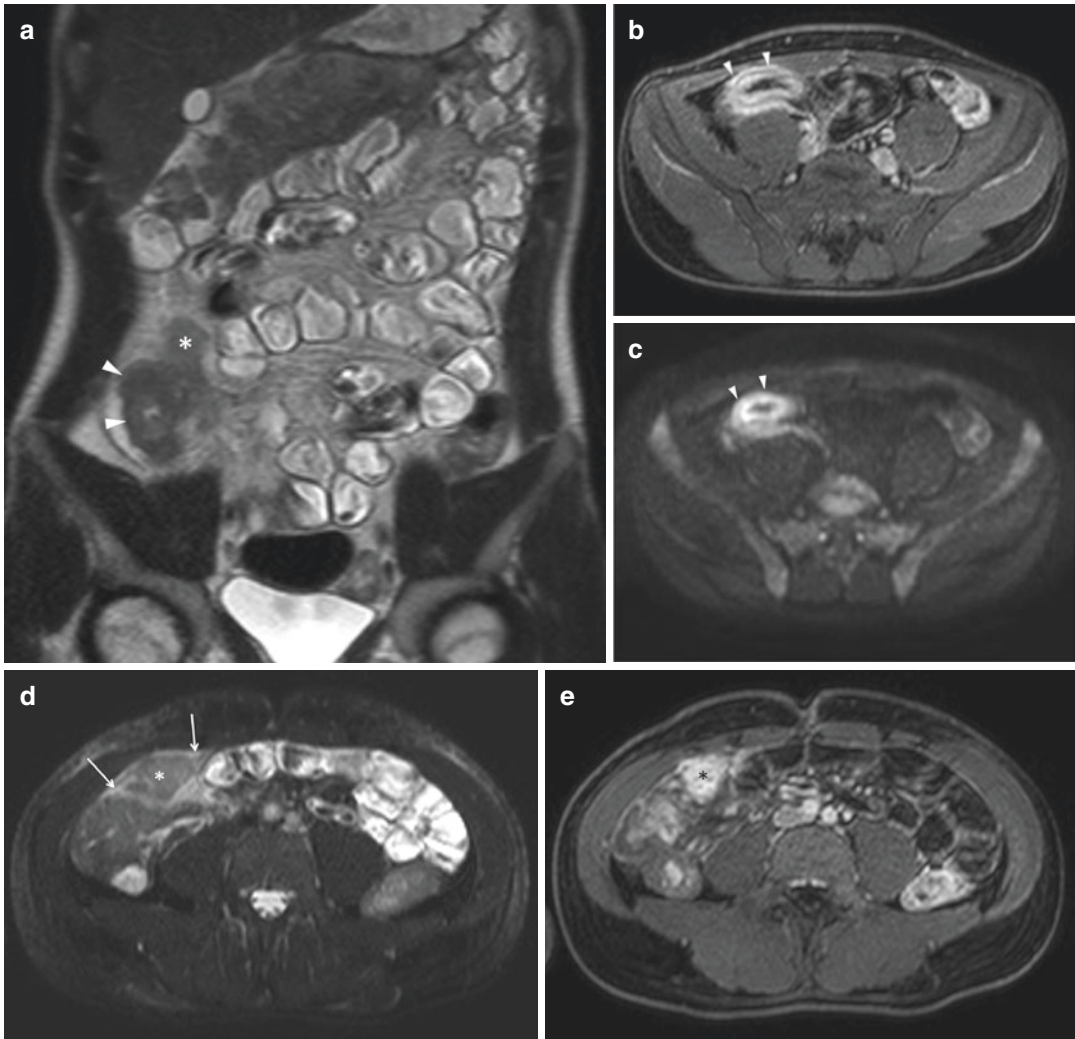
A 28-year-old male patient suffering from Crohn's disease. Coronal T2-w HASTE image (a) displays a wall thickening of the last ileal loop (arrow) with a layered appearance on axial GE T1-w scan with fat saturation (b) and on 800 s/mm² b-value image (c). Coronal T2-weighted HASTE (a) and axial T2-weighted HASTE
